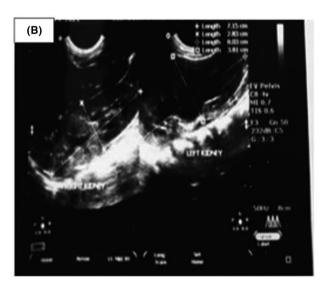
Transverse and longitudinal abdominal ultrasound images show lobulated heterogeneous solid mass in the urinary bladder lumen (A) and moderately dilated left renal calyces (B)
